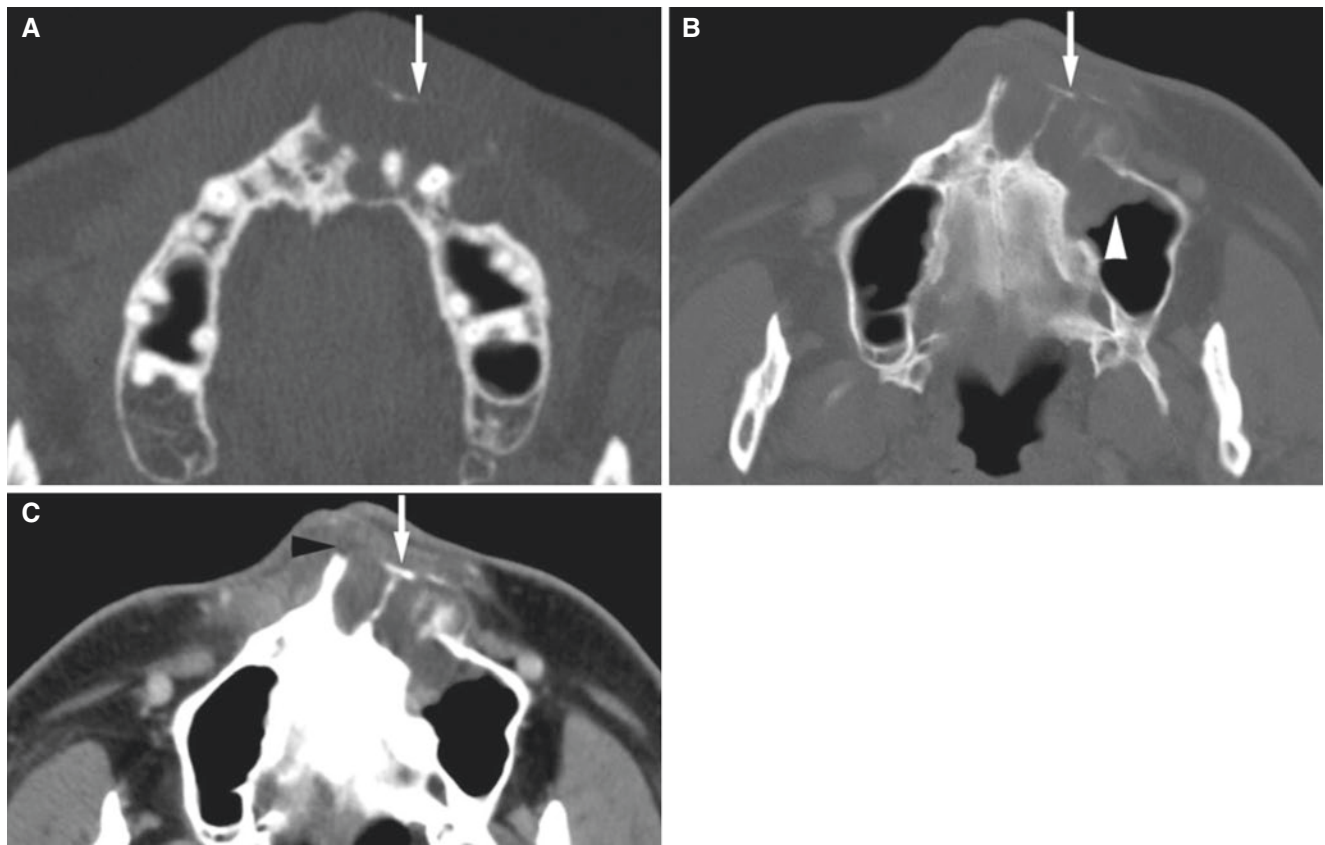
Glandular odontogenic cyst, maxilla; 47-year-old male with painless swelling of mucobuccal fold. (A) Axial CT image shows radiolucency between teeth with expanded, destroyed cortical outline (arrow). (B) Axial CT image shows process (arrow) with no cortical
